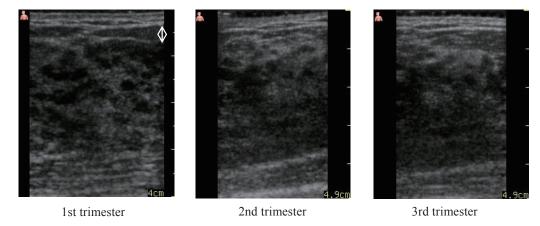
Pocket ultrasound images of the subject 2 (30s, multipara) who was easy to observe the change in image finding that the subcutaneous fat becomes thin
